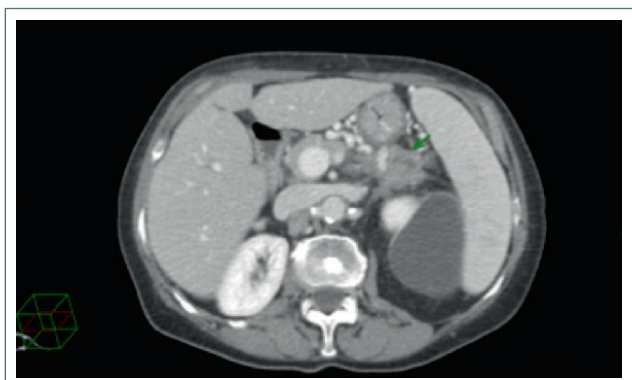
Abdominal CT scan – venous phase (November 2015): a large mass (4 cm) in the pancreatic tail is showed (green arrow).
